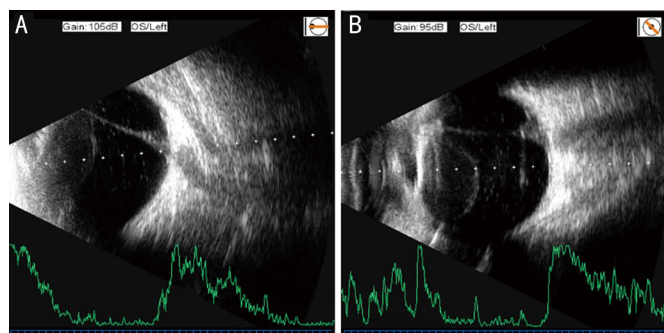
Misdiagnosed case of PHPV A: PHPV diagnosed by conventional B-ultrasonography; B: PHPV combined with vitreous hemorrhage in the anterior segment diagnosed by Pano-immersion B-scan ultrasonography. PHPV: Persistent hyperplastic primary vitreous.
